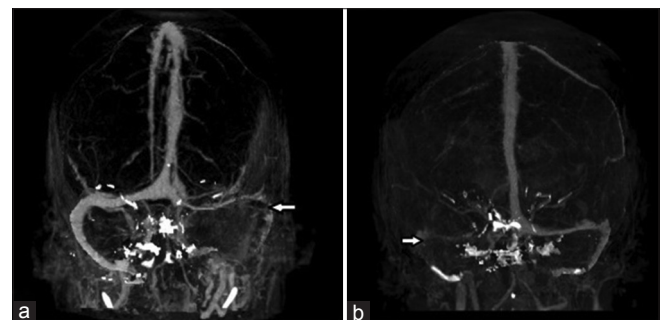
Maximum intensity projection images of computed tomography venography showing (a) nonvisualization of left transverse and sigmoid sinus and (b) nonvisualization of left transverse and sigmoid sinus
